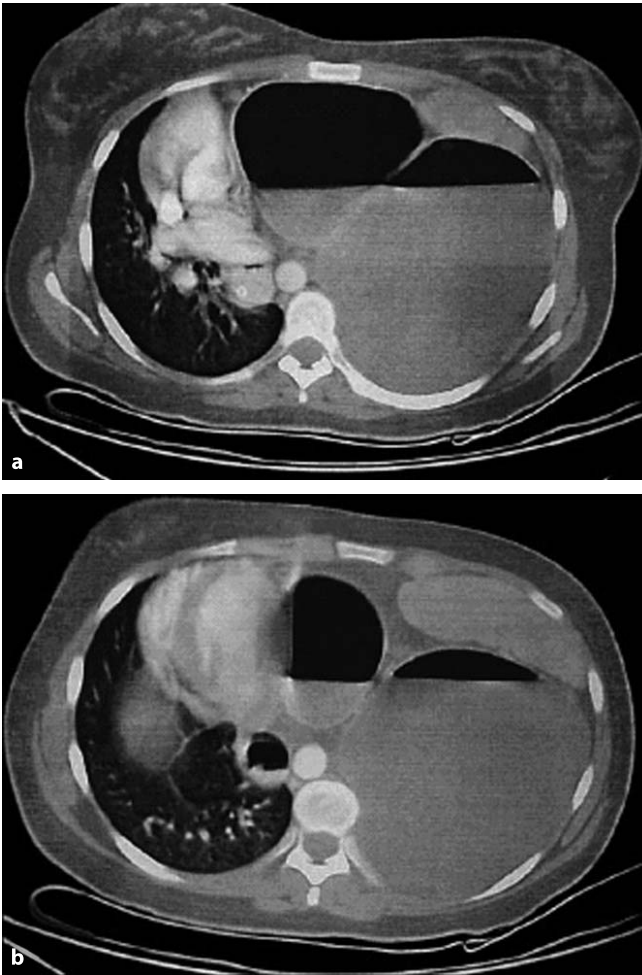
a, b. Axial CT scan through the lower thorax. a Air fluid level in a distended stomach with shift of the heart to the right. The “bubble” on the *right* represents the gastric antrum. Note the nasogastric tube in the distal esophagus to the right of aorta. b A lower cut with the spleen visible on the *left*. The *left bubble* represents the gastric fundus. Note the “transition line” between the two “bubbles” representing the site of the volvulus
